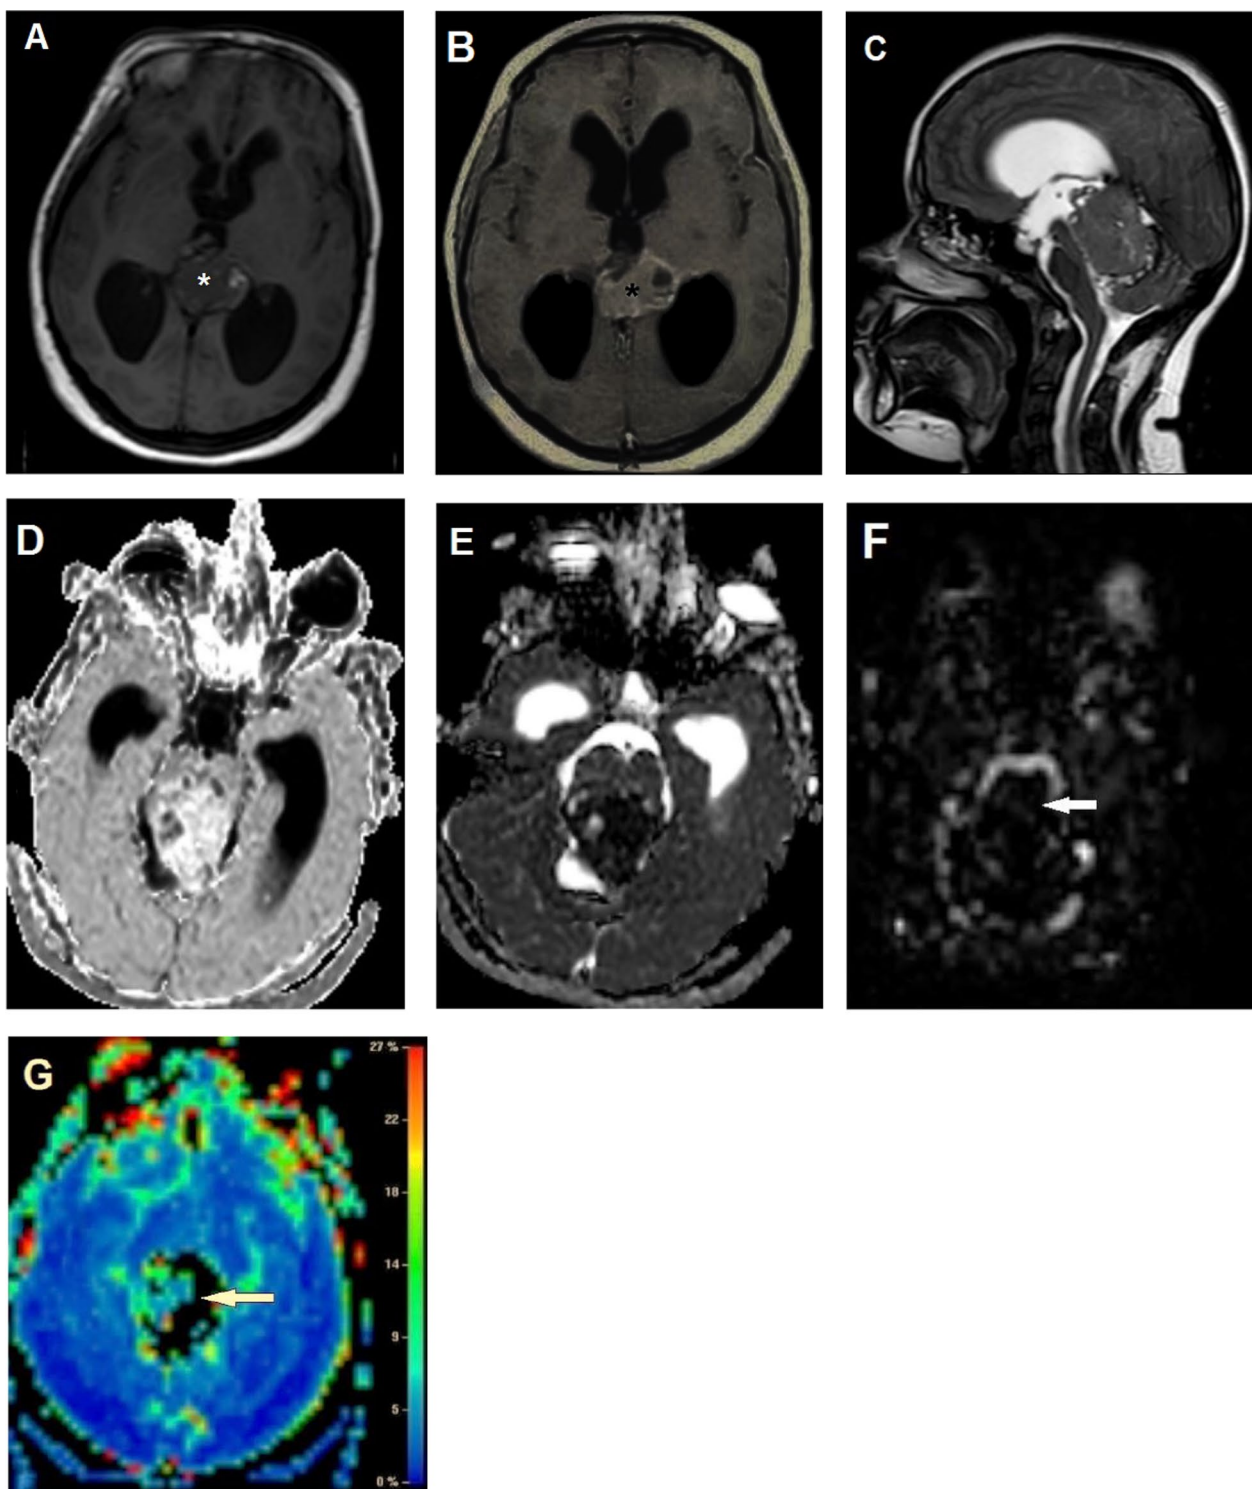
A 15-year-old girl patient with WHO grade 4 medulloblastoma. Images show a fourth ventricular mass of non-homogenous signal intensity (asterisk) displaying low SI with hemorrhagic foci of high SI on axial T1WI (A) with heterogeneous enhancement on post contrast axial T1WI (B). Its origin from the roof of fourth ventricle can be demonstrated in sagittal T2WI (C). It shows restricted diffusion in the form of high SI on DWI (b1000 image) and low SI on axial ADC grayscale map (D, E). There is mixed perfusion of the lesion (white arrows) on Axial ASL grayscale and color CBF maps (F, G)
